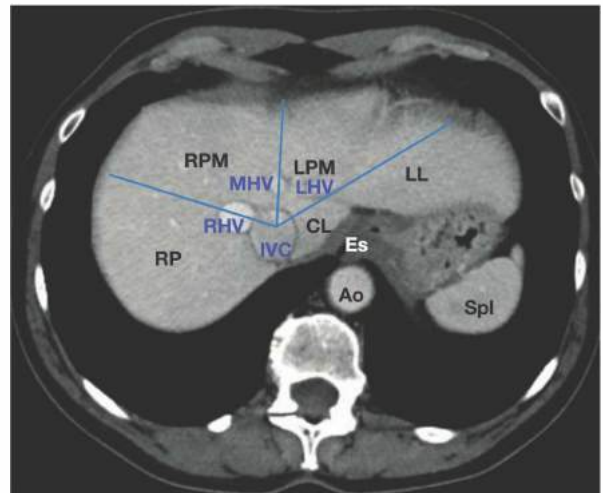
• Axial CT image, venous phase, showing the right (RHV), middle (MHV), and left (LHV) as they enter the inferior vena cava (IVC). Blue lines show approximate direction of hepatic veins as they traverse the liver. Individual liver sectors are labeled (RL, right lateral; RPM, right paramedian; LPM, left paramedian; LL, left lateral). Also labeled are the caudate lobe (CL), esophagus (Es), aorta (Ao), and spleen (Spl).
